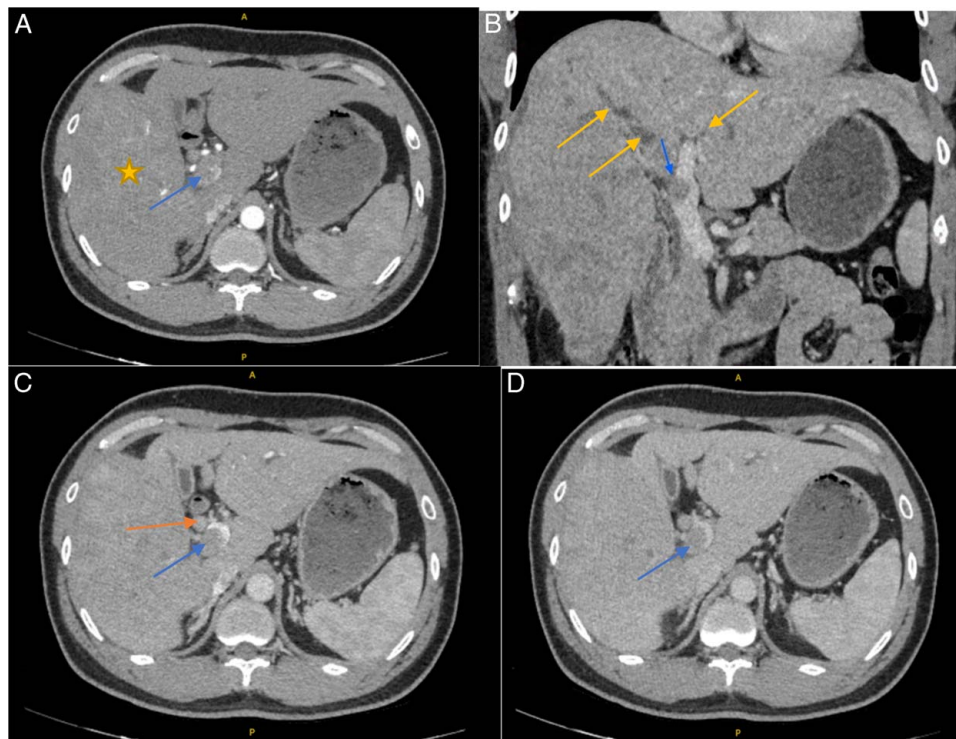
Abdominal computed tomography scan show a large tumour in the right liver with characteristics of hepatocellular carcinoma (HCC). [(A) Arterial phase. (B, C) Venous phase. (D) Portal phase) HCC tumour (yellow star) with portal vein tumour thrombus in the right portal vein and the portal bifurcation (blue arrow), without invasion of the left portal vein. Dilatation of the intrahepatic bilateral bile ducts (yellow arrows) due to obstruction by bile duct tumour thrombus in the bile duct confluence (orange arrow).
